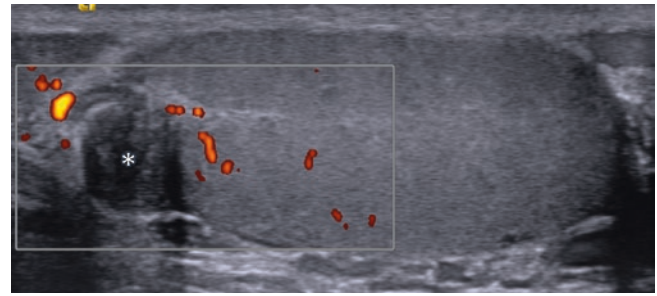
A 56-year-old with painless right scrotal swelling after recent right nephrectomy with reported gonadal vein tie off/thrombosis. US of the scrotum shows an intratesticular, well-circumscribed, lobulated, heterogeneously hypoechoic mass without internal flow on Power Doppler ultrasound (asterisk). The clinical history and imaging appearance suggest partial/focal testicular infarction, and involution was documented on follow-up US (not shown)
